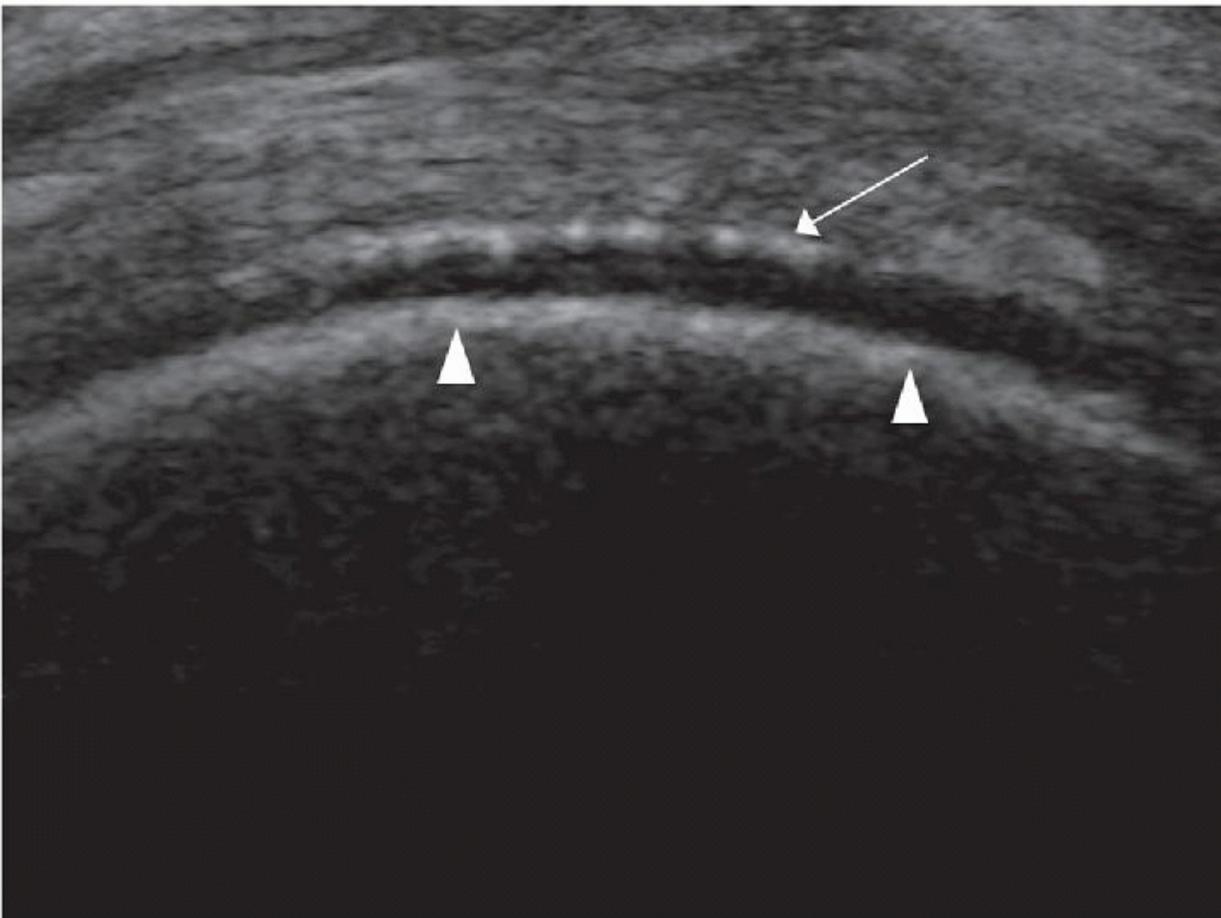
Ultrasound examination of the femoral articular cartilage of the knee of a patient with gout. The double contour appearance due to echogenic crystal deposition on the surface of the cartilage (arrow) is characteristic of gout. Note the subchondral bone (arrowheads).
